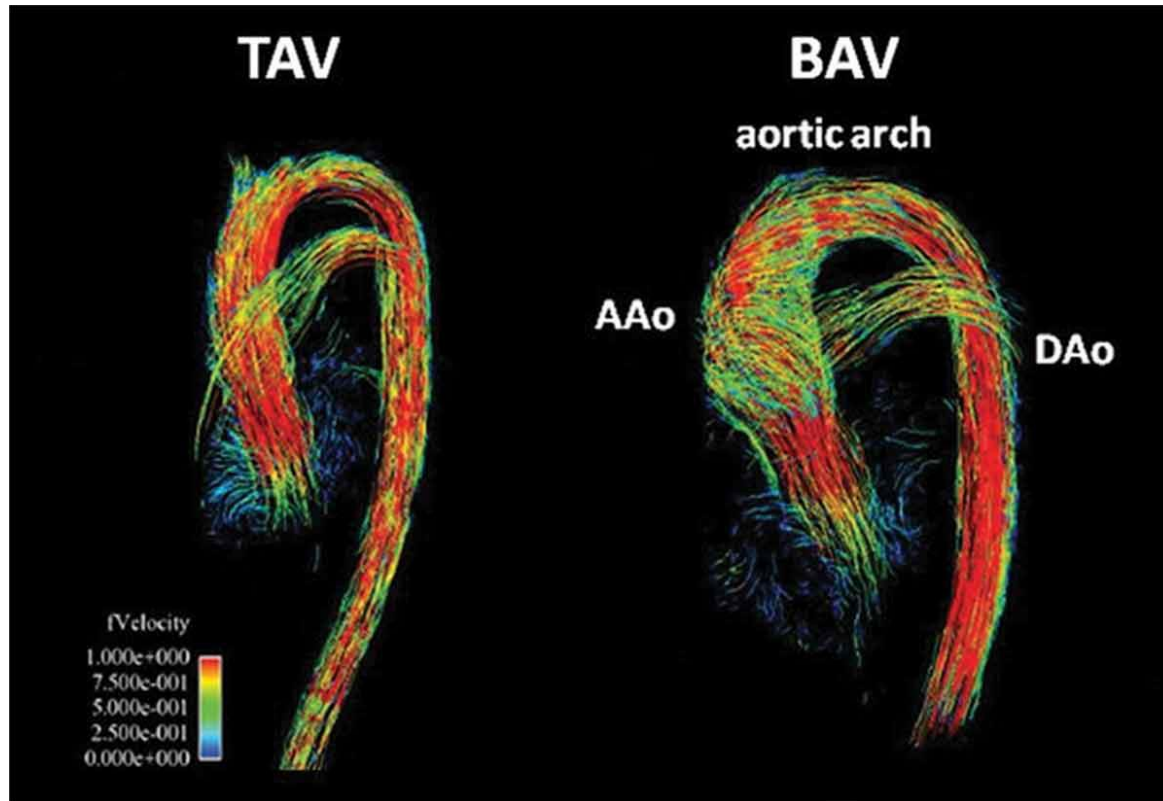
4D flow MRI of the aortic valve and aorta. Comparison of 4D flow MRI streamlines of the aortic flow in a patient with tricuspid aortic valve (TAV) and a patient with bicuspid aortic valve (BAV). Reproduced from Meierhofer *et al.* [66] with permission from the Oxford University Press.
